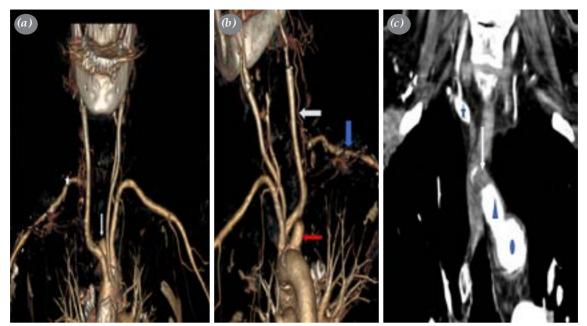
(a) Three-dimensional CTA anterior view; the white arrow shows ARSA completely occluded behind the esophagus after exit, and the white star shows the distal right subclavian artery filling the right vertebral artery. (b) Three-dimensional CTA posterior oblique view; the white arrow indicates the right vertebral artery filling the proximally occluded ARSA, the blue arrow shows the distal part of ARSA, and the red arrow shows the proximal part of the ARSA (c) Computed tomography angiography coronal section; the blue circle shows the descending aorta, the blue triangle shows the ARSA, the white arrow shows the occluded segment of the ARSA, and the blue star shows the distal right subclavian artery filling from the right vertebral artery.
